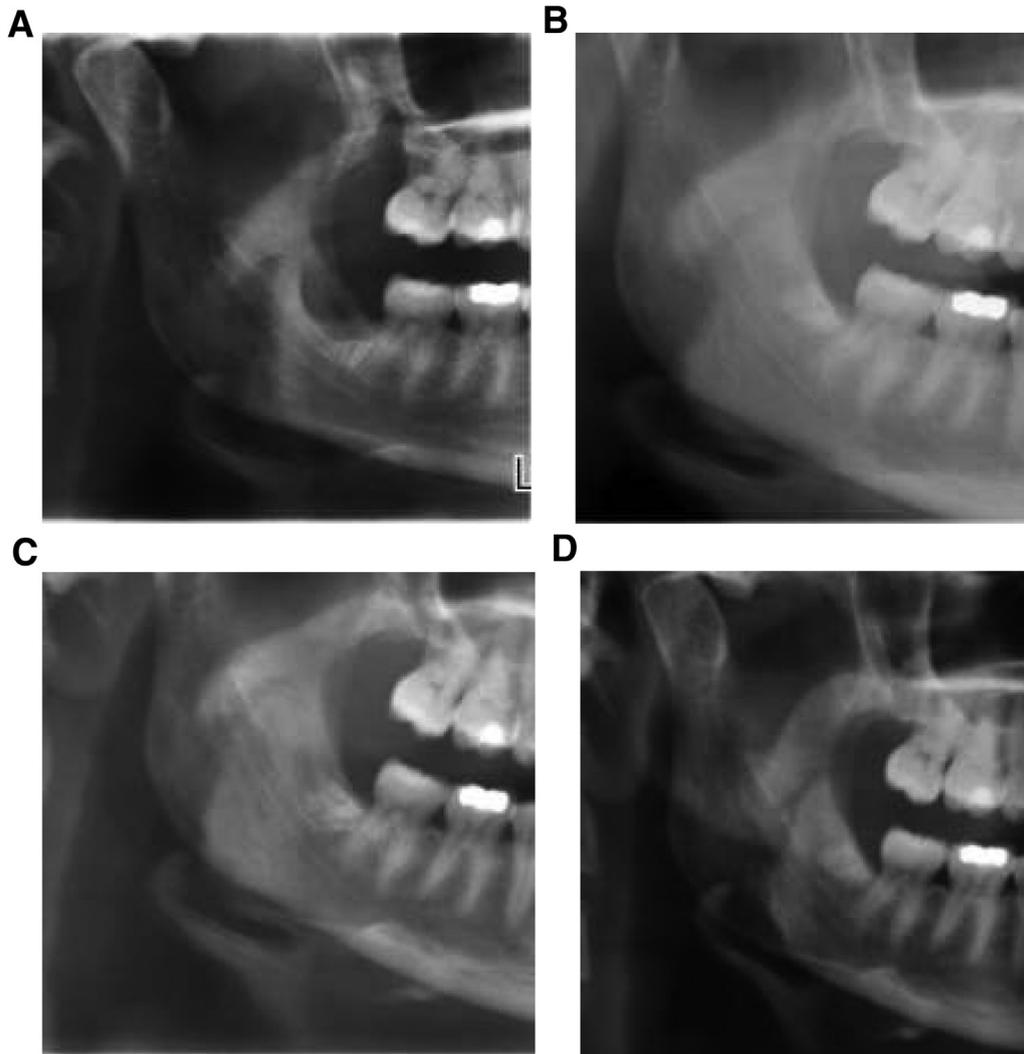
Example of radiographic follow-up of a coronectomy of a right side mandibular third. A, The postoperative image. B, At 1-year follow-up. C, At 3-year follow-up. D, At 5-year follow-up.
